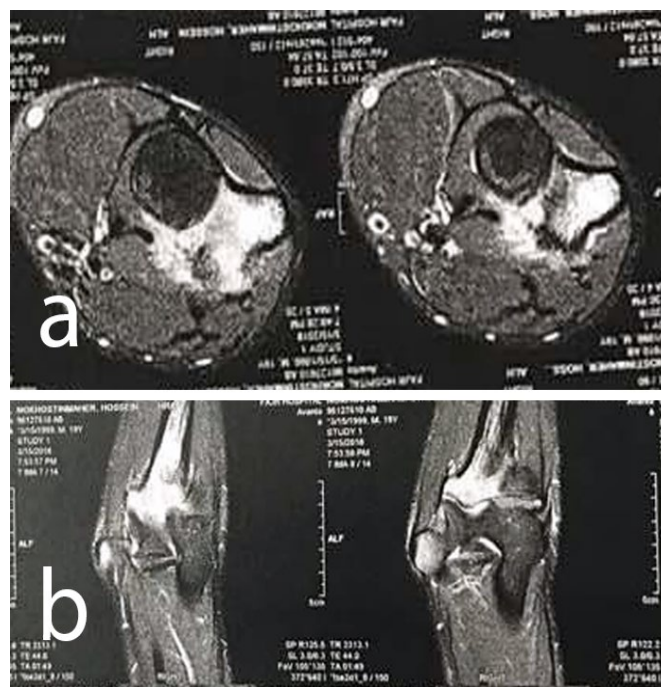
Axial (a) and coronal (b) MRI of the elbow show diffuse bone marrow edema of the proximal ulna
